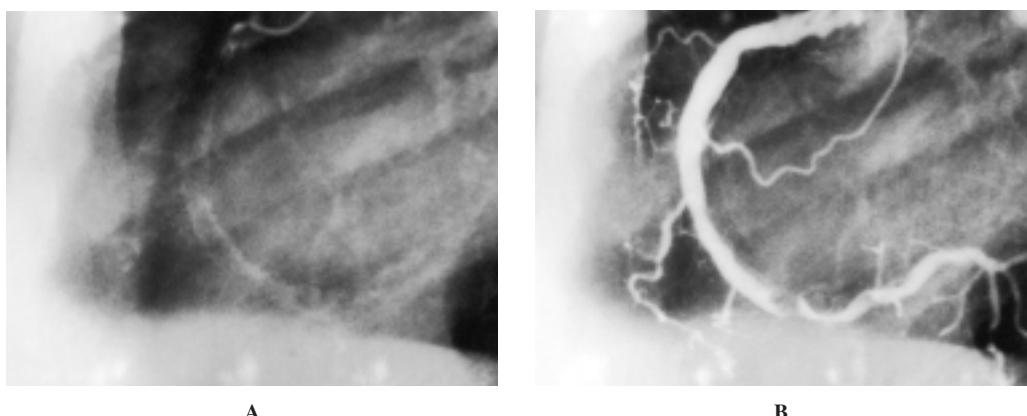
Left anterior oblique view of the right coronary artery showing: widespread calcification of the arterial wall at direct X-ray examination (A); widespread luminal narrowing and a critical stenosis at the distal segment after contrast medium injection (B).
